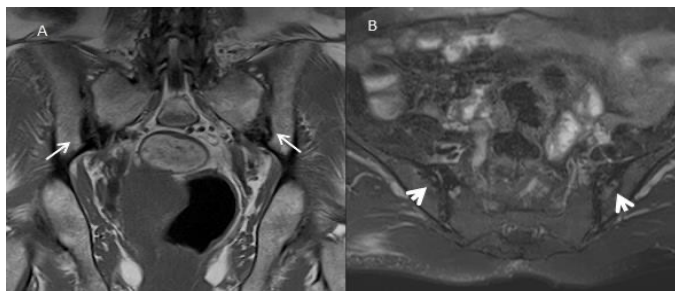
A 38-year-old grand multiparous patient with OCI and PCS findings together and who has intermittent lower back pain for 3 years (A) Coronal oblique T1 weighted magnetic resonance image show symmetric sclerosis of iliac subchondral bone as very dark signal. Note bilateral SIJ spaces and surfaces are normal (white arrows). (B) Oblique axial T1-weighted postcontrast image demonstrates enlarged parauterine vein of the largest measuring 8.5 mm in diameter on the right side (thick arrow)
